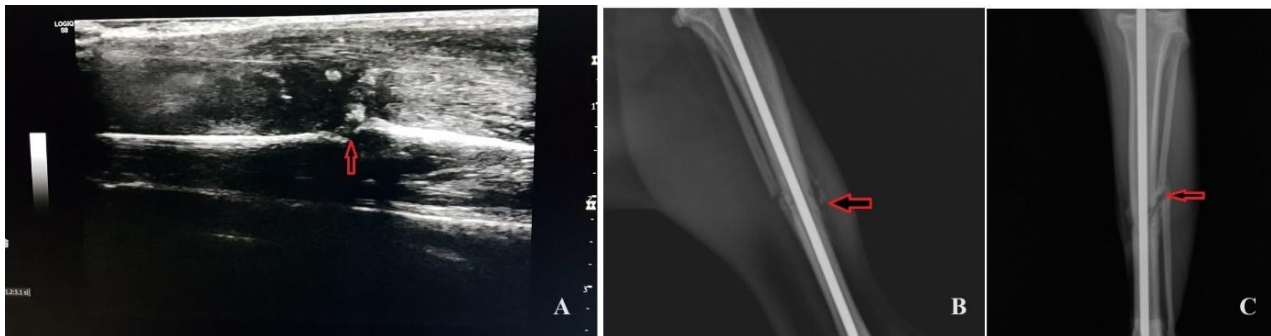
A. Postoperative 20th day B-mode ultrasonography image of Case 2. Red arrow: Fracture line. B. Postoperative 20th day mediolateral radiographic image. Red arrow: callus C. Postoperative 30th day anteroposterior radiographic image. Red arrow: Fracture line.
